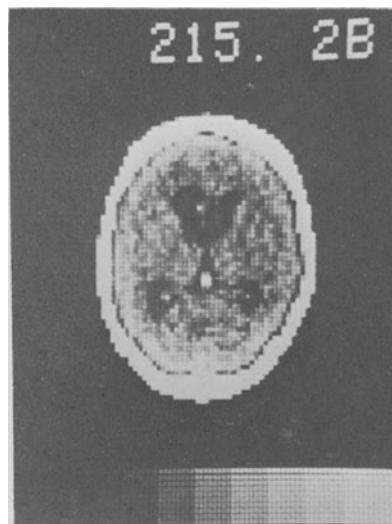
Example of a CT scan in the skull of a patient with a brain tumor. The streaky, cube-like appearance of the image (in this case with a matrix of  $160 \times 160$  points) is typical of the method.
